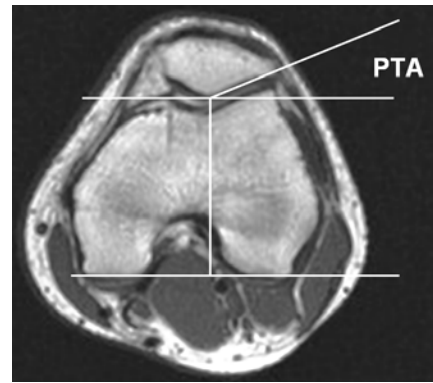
MRI based PTA measurement.
